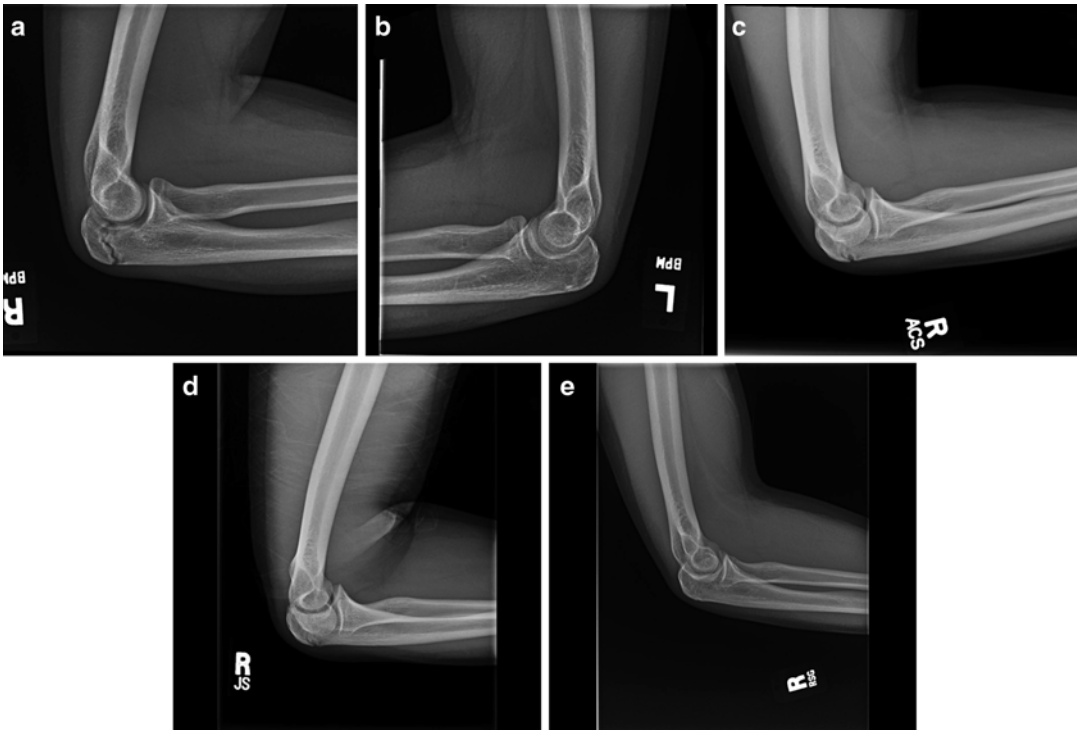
A 14-year-old baseball pitcher with 2 months of right elbow pain. (a) Lateral radiograph of the right elbow showing widened, irregular olecranon apophysis. Notice the difference when compared to the contralateral elbow (b). A period of complete rest was initiated. (b) Lateral radiograph of the left elbow obtained at the same time as (a) showing fused olecranon physis. (c) Lateral radiograph of the right elbow obtained after a 2-month
